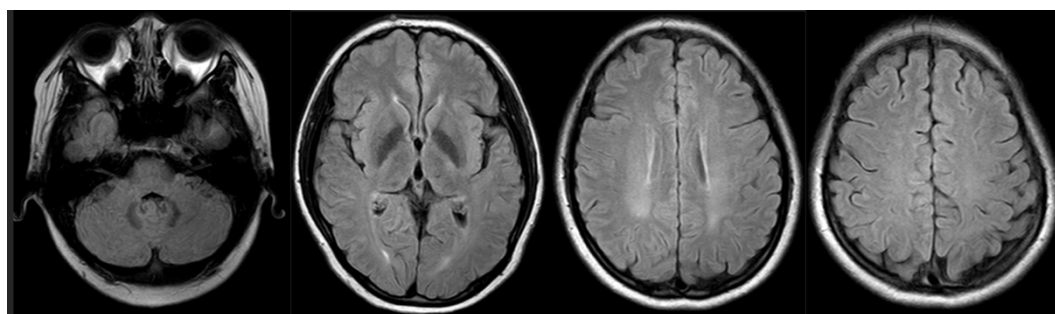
MRI head with contrast (FLAIR sequences) five months on immunosuppressive and immunomodulatory therapy. Mild chronic multiple ICH in the left cerebellum, bilateral thalamus, bilateral parietal lobes (predominantly on the left side), and left temporal lobe are no longer observed. No post-contrast enhancements. No perifocal edema.
